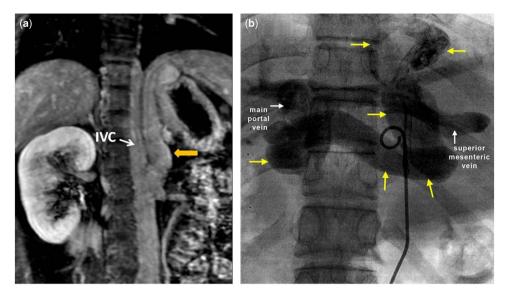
(*a*) Abdomen contrast CT showing the origin of the anomalous vein from the inferior caval vein (IVC) and its upward and leftward course towards the midline liver. (*b*) Selective venogram of the Abernethy malformation showing the tortuous course of the vein (yellow arrows) and its termination by joining the main portal vein (white arrow). A branch of the superior mesenteric vein (white arrow) is seen joining the anomalous vein.
